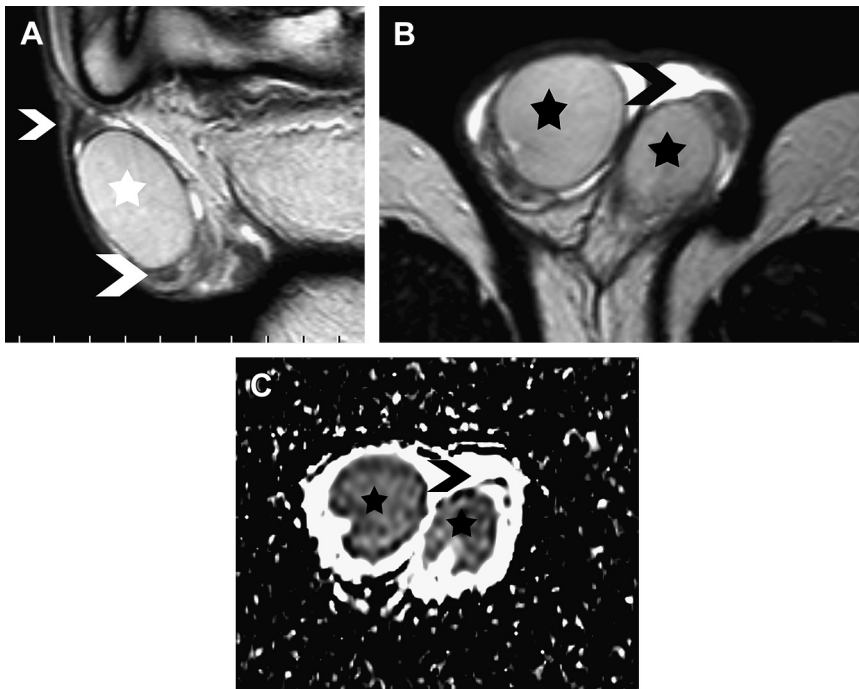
Normal findings in a 21-year-old man. (A) Sagittal and (B) transverse T2-weighted images show normal hyperintensity of both testes (*asterisks*). The left epididymis (head and tail, *arrowhead*) appears hypointense. A small amount of hydrocele is noted bilaterally. (C) Transverse ADC map ($b = 900 \text{ s}/\text{mm}^2$) depicts hyperintensity of the left epididymal head (*arrowhead*). The ADC values of testicular parenchyma (*asterisks*) are $0.87 \times 10^{-3} \text{ mm}^2/\text{s}$ (right testis) and $0.92 \times 10^{-3} \text{ mm}^2/\text{s}$ (left testis), and the ADC value of the left epididymis is $1.69 \times 10^{-3} \text{ mm}^2/\text{s}$ (*arrowhead*).
